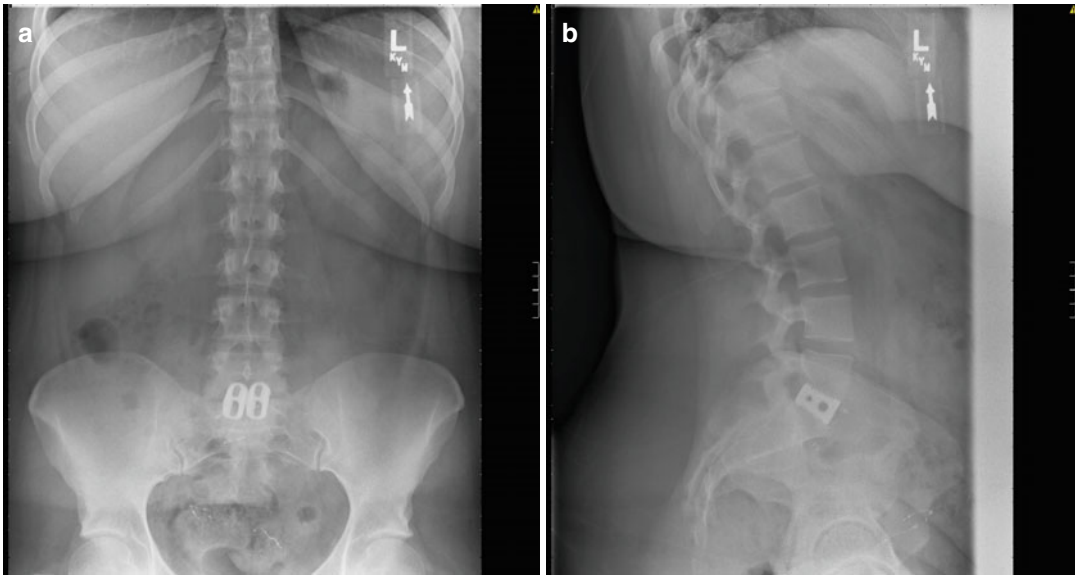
Posteroanterior (a) and lateral (b) radiographs demonstrating L5–S1 anterior lumbar interbody fusion with titanium lordotic cage
